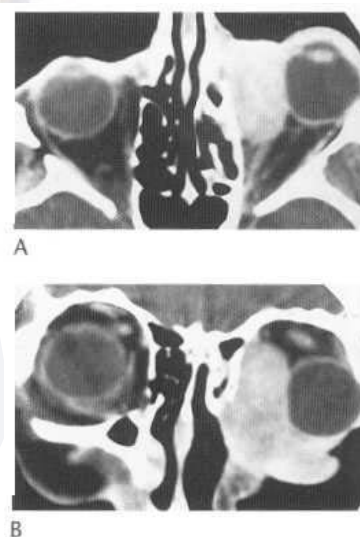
Squamous-cell carcinoma of lacrimal sac. Axial (A) and coronal (B) CT scans demonstrate a large enhancing mass in the inferomedial portion of the left orbit. There is proptosis and lateral deviation of the left globe. Bone windows (C) demonstrate destruction of medial orbital wall and nasolacrimal duct canal. Normal bony canal is seen on right (arrow).
